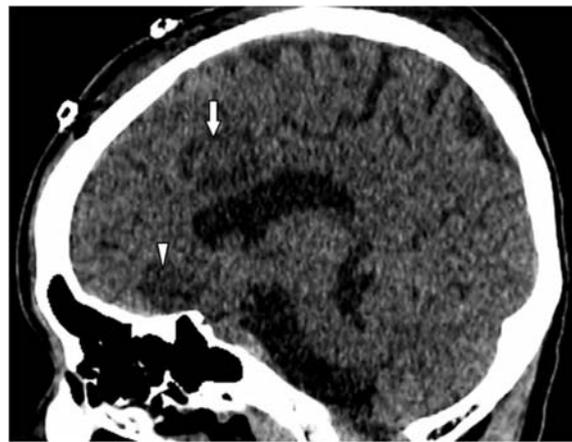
Sagittal CT of the brain after limbic leucotomy showing combined lesions of anterior cingulotomy (arrow) and subcaudate tractotomy (arrowhead).
